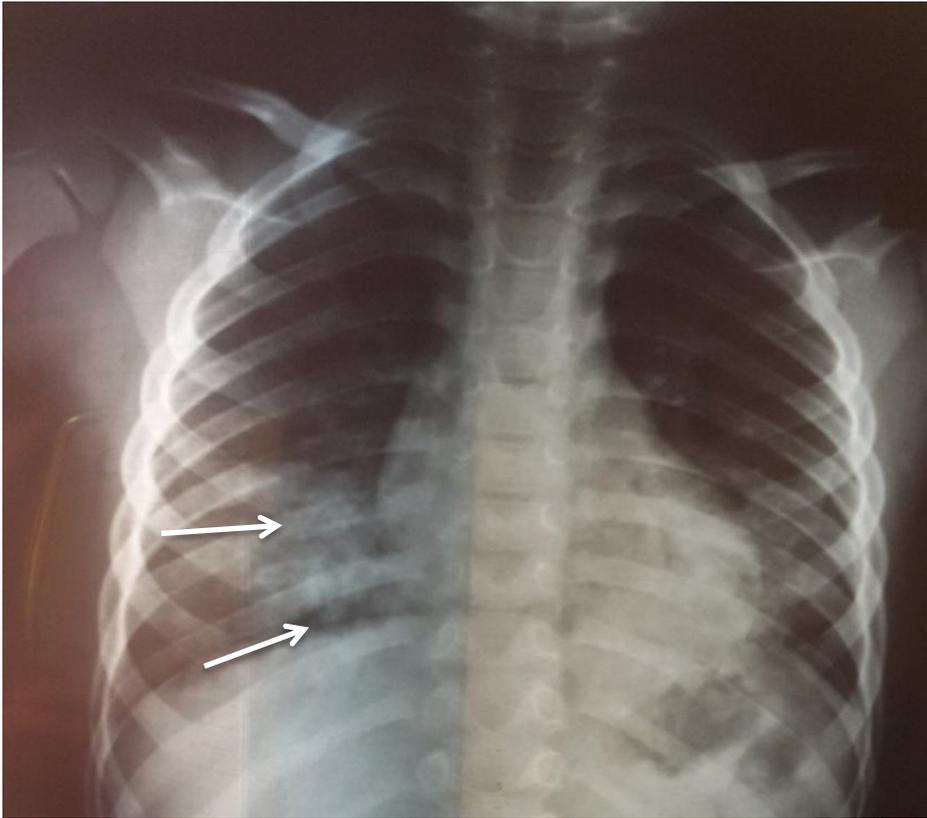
Chest x-ray of male patient 3 years old with kerosene toxicity showing right basal pneumonic patches (arrows)
